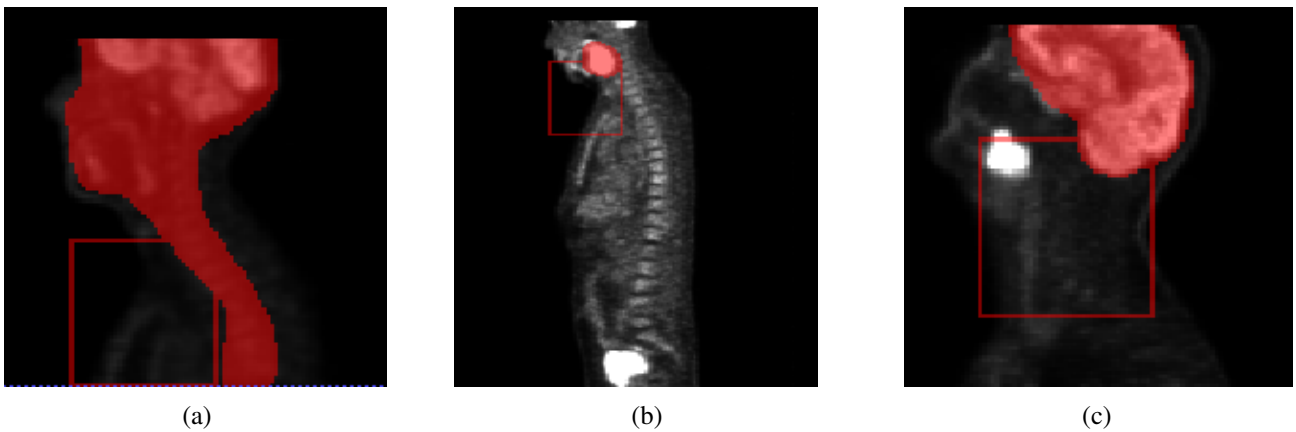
Examples of 2D slices of failed extended oropharyngeal region detection. (a) The SUVs are low due to erroneous information in the DICOM metadata resulting in an incorrect segmentation of the brain, thus of the oropharynx, (b) The brain is outside the image resulting in a wrong segmentation and (c) The head is tilted and the tumor is high on the z-axis, resulting in a bounding box too low.
